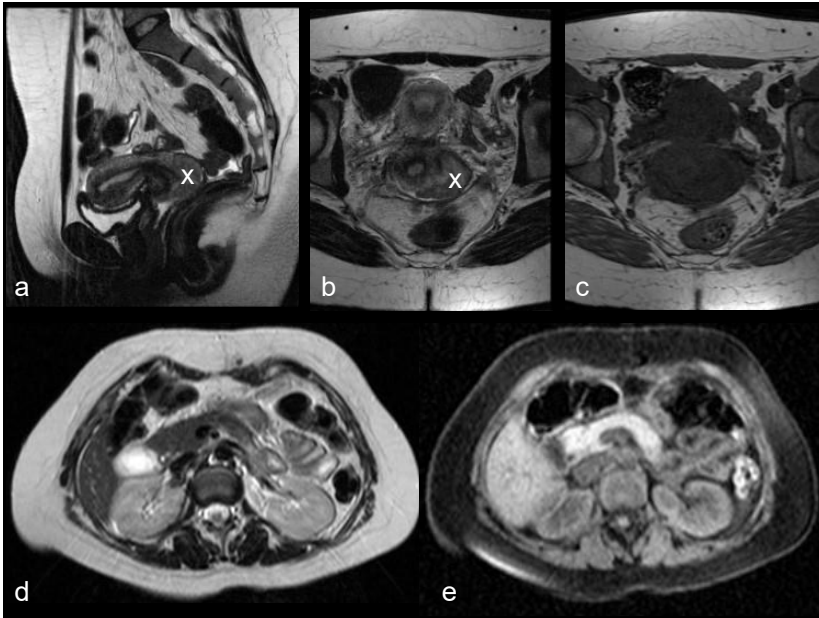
MR protocol A: T2-weighted sagittal (a) and transaxial (b) images of the pelvis, T1-weighted transaxial images of pelvis (c) and transaxial T2-weighted images of the upper abdomen (d) and T1-weighted images of the upper abdomen (e). A cervical tumour bulging into the left fornix is indicated with “x.”
